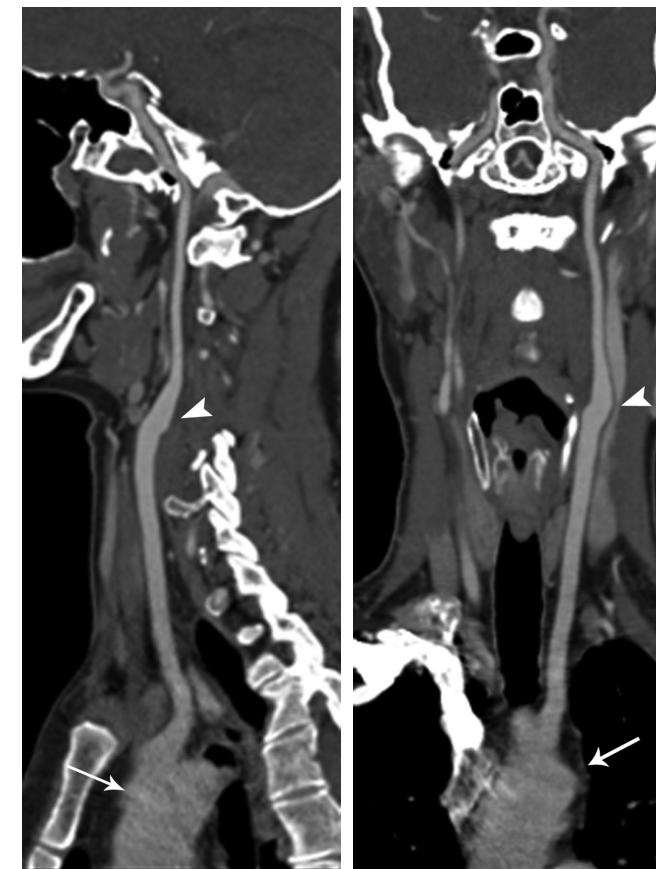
CT angiograms of left carotid artery. (a) Sagittal and (b) coronal curved planar reformations from the aortic arch to the carotid siphon. The curved planar reformations demonstrate a homogeneous attenuation in the artery from the aortic arch (arrow) through the carotid bifurcation (arrowhead) to the intracranial circulation.
